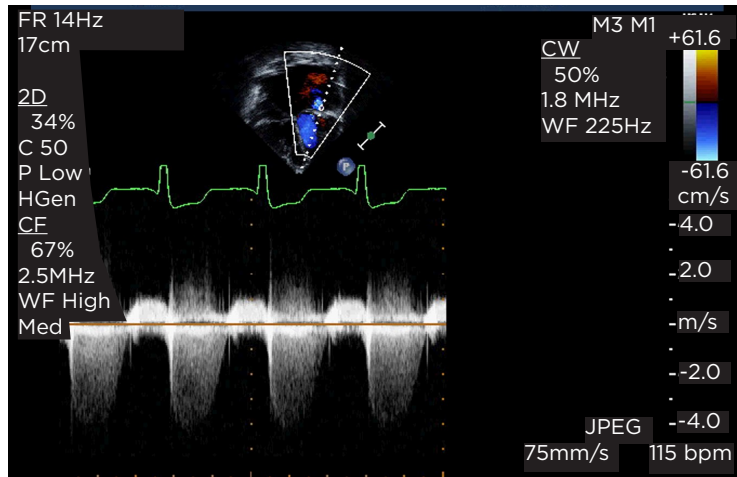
Doppler regurgitant flow mitral valve 1 pulsed wave 4 m/s.
